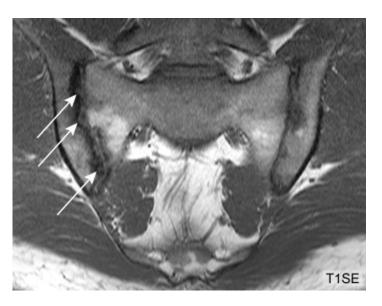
T1-weighted spin echo (T1SE) sequence. Erosion in the right ilium extending across the entire joint (arrows).
